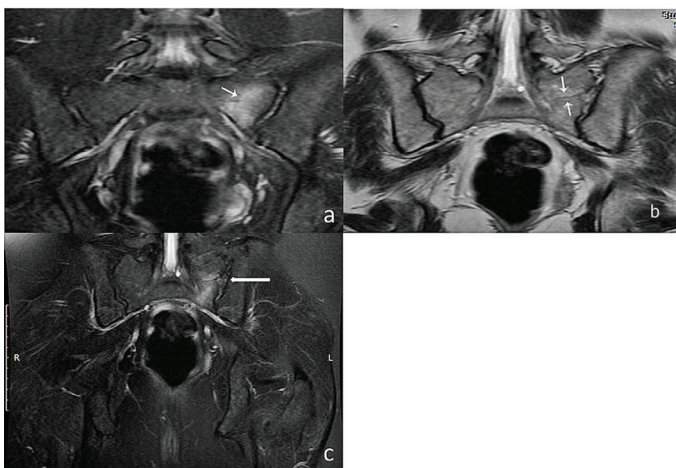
(a) Coronal STIR images demonstrating the fracture line in the left sacrum (arrow). (b,c) Coronal T2 and Coronal T2 fr FSE FSat MRI images of the same fracture (arrows)
